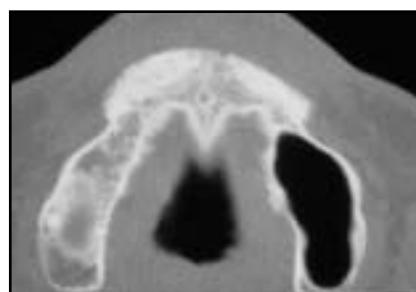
CT scan, postoperative view.
